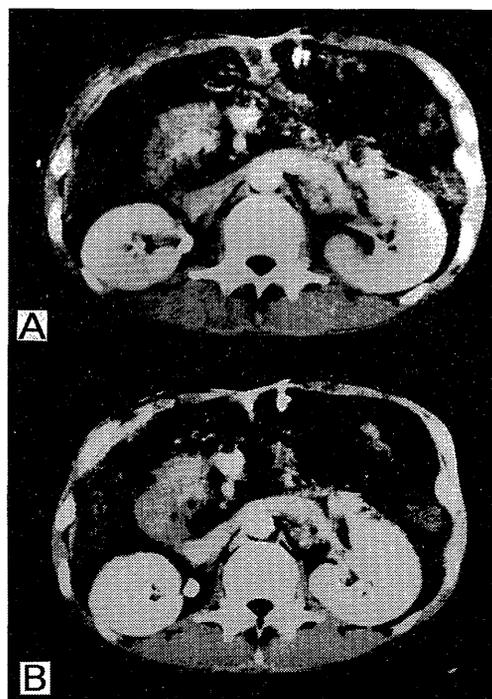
The CT images before and after ESWL in case 1.
